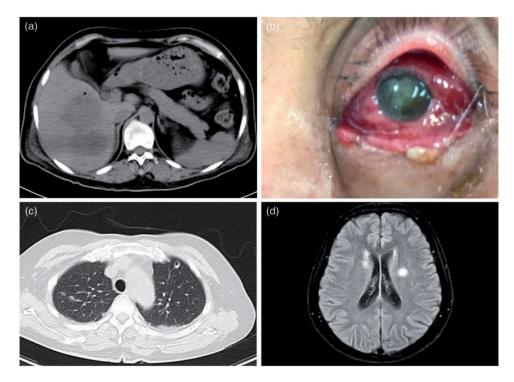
Representative images from an adult patient with cryptogenic pyogenic liver abscess with metastatic infection: (a) image from abdominal computed tomography (CT) scan in which two large polylobar right lobe hypodense lesions can be clearly identified; (b) photograph of the eye showing a turbid lens and swollen conjunctiva with purulent exudation; (c) image from chest CT showing a hole filled with liquid in the upper left lung, suggesting an interstitial pulmonary and bilateral pleural effusion; and (d) image from magnetic resonance imaging scan of the head performed one week following presentation revealing multiple 5mm ring-enhancing lesions.
